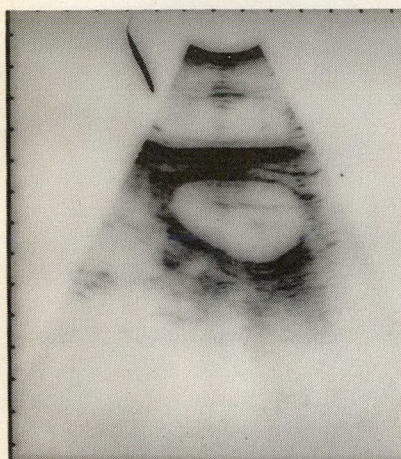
Ultrasonogram shows cystic mass in left lobe of thyroid gland.
